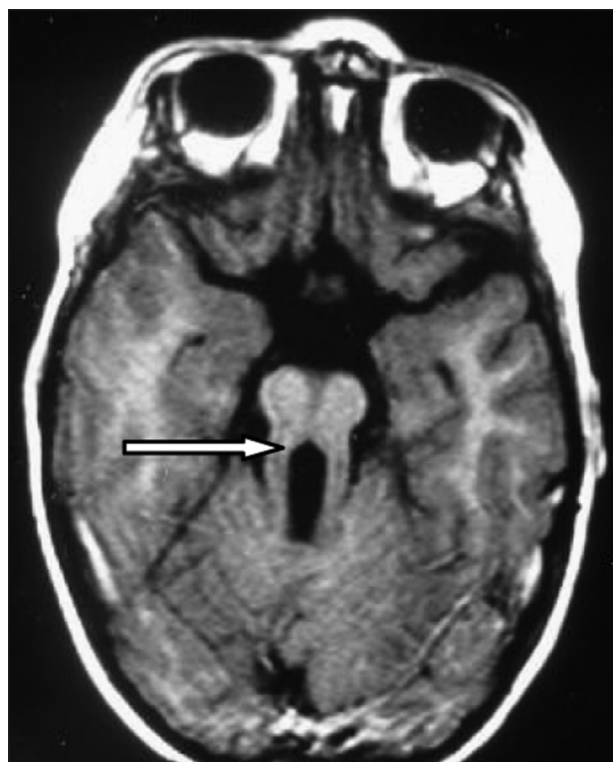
Molar tooth sign (arrow) in axial MRI images, for a patient with Joubert syndrome.
